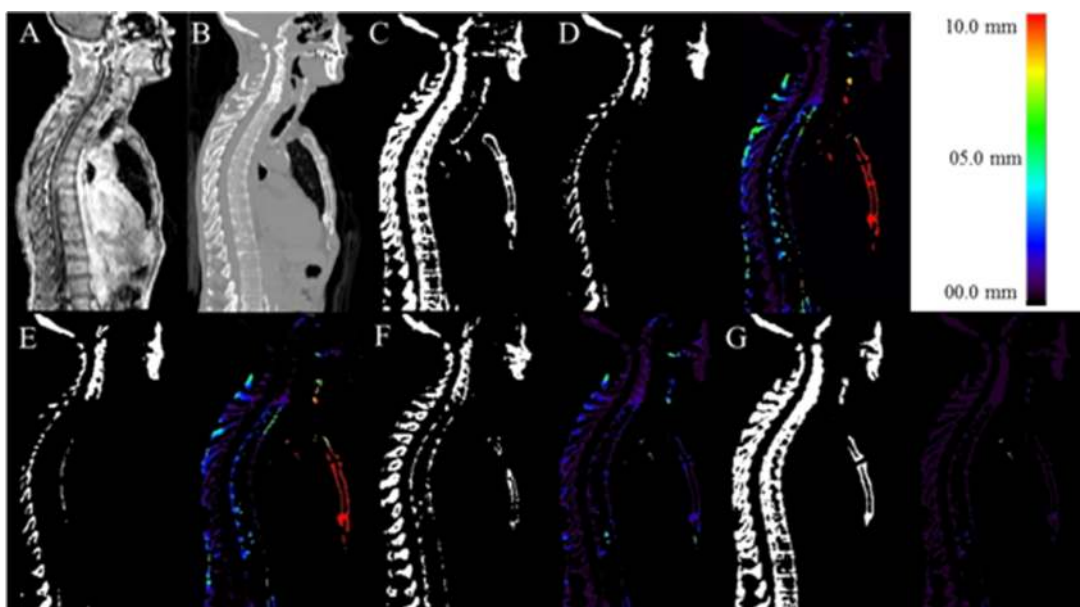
Representative slice of bone segmentation from MR image along with corresponding error distance map. (A) In-phase MR image, (B) corresponding CT image, (C) binary image of reference bone, (D) Hofmann's method (Ref. 34), (E) arithmetic mean of whole aligned dataset, (F) global weighting atlas fusion, and (G) local weighting atlas fusion. Reprinted with permission from Arabi and Zaidi, "Comparison of atlas-based bone segmentation methods in whole-body PET/MRI," in *IEEE Nuclear Science Symposium and Medical Imaging Conference (NSS/MIC)*, Seattle, WA, 2014. Copyright 2014 by © IEEE.
